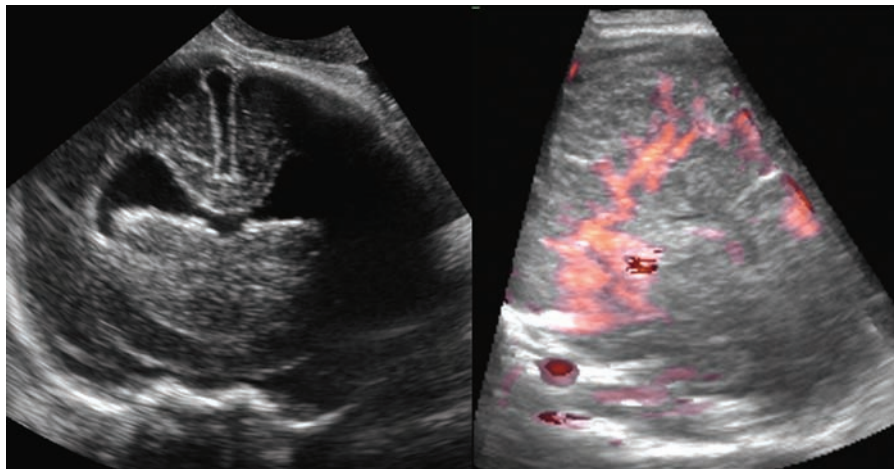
Fetus with trisomy 13 and lobar holoprosencephaly as seen by transvaginal ultrasound (left). 3D power Doppler shows the aberrant bizarre course of the anterior cerebral artery.
